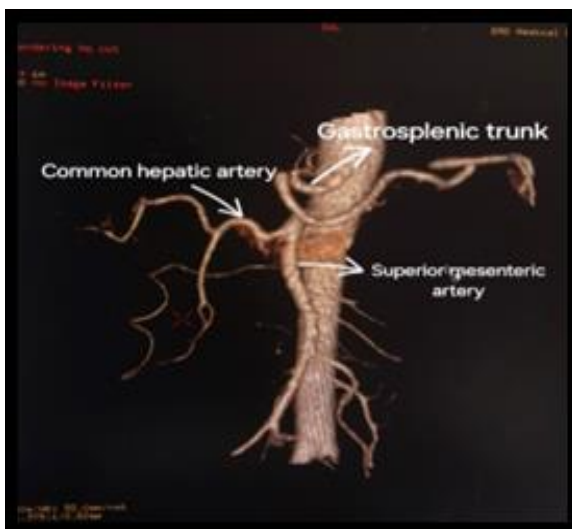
Computed tomography arterial phase images showing common hepatic artery originating from superior mesenteric artery (SMA) (Uflacker's type V), with a separate Gastro-splenic trunk arising from abdominal aorta
